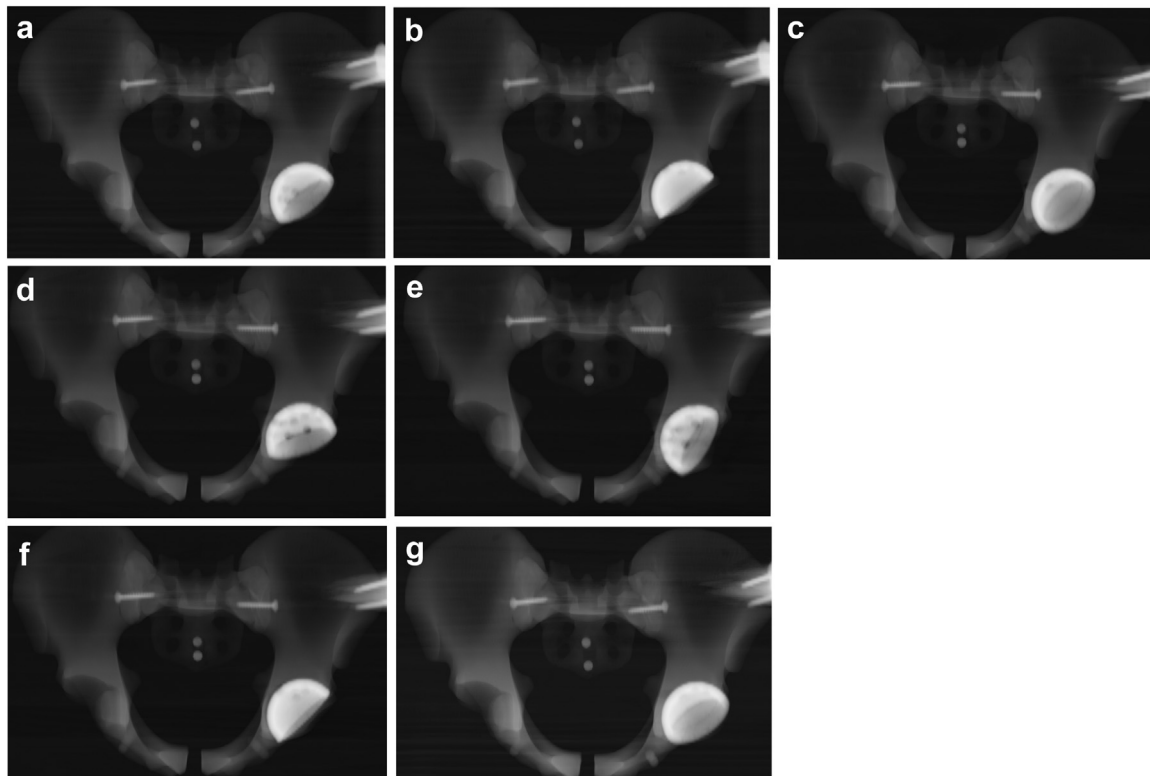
Digital reconstruction radiographs. (a) Neutral, (b) 20° sagittal posterior tilt, (c) 20° sagittal anterior tilt, (d) 20° coronal right tilt, (e) 20° coronal left tilt, (f) 20° axial right rotation, and (g) 20° axial left rotation.
